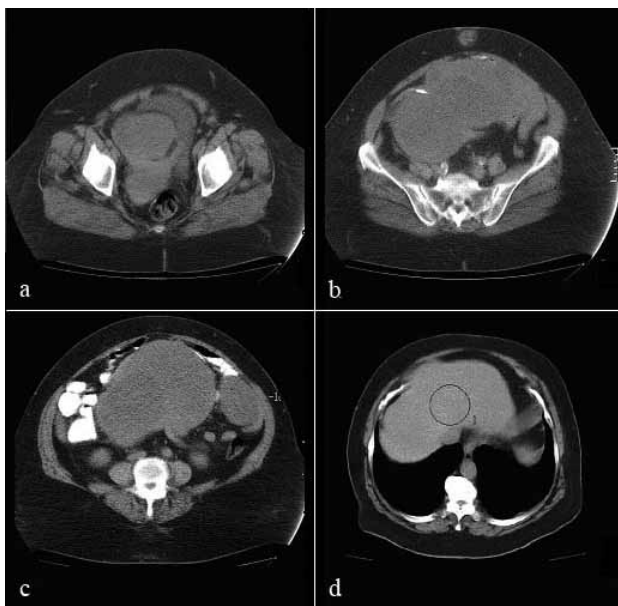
Computed tomography (CT) findings before surgery a) tumor in the lesser pelvis b) tumor in the central part of abdomen c) tumors occupied the left and central part of the abdomen d) liver without suspicious changes.
